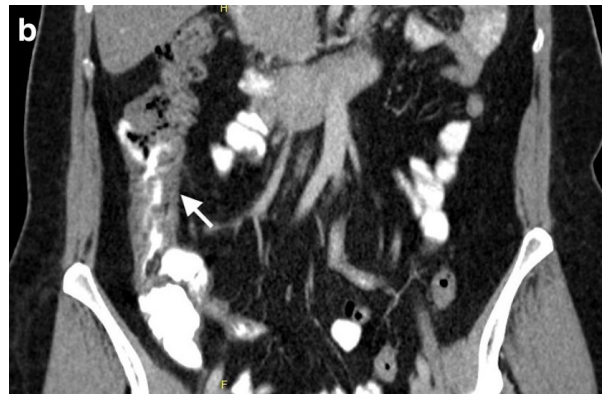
A 39-year-old woman with coronavirus disease-2019 presented with abdominal pain. Axial (a) and coronal (b) computed tomography images demonstrating the thickening of the ascending colon wall (arrows).
